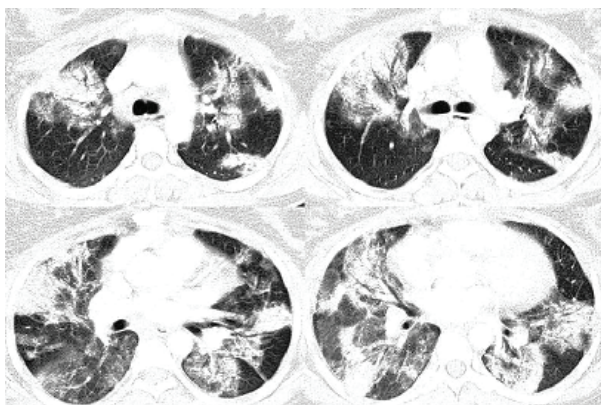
CT scan shows bilateral alveolar opacities
